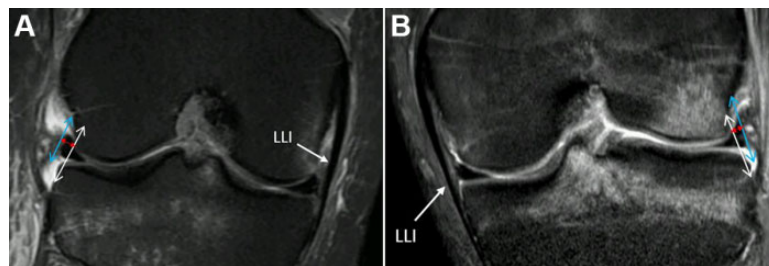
Measurement of meniscal extrusion (red arrow) between the lateral edge of the lateral meniscus (blue arrow) and the lateral edge of the lateral tibial plateau and lateral femoral condyle (white arrow) on coronal magnetic resonance imaging slices through the medial collateral ligament. (A) Right knee. (B) Left knee.
